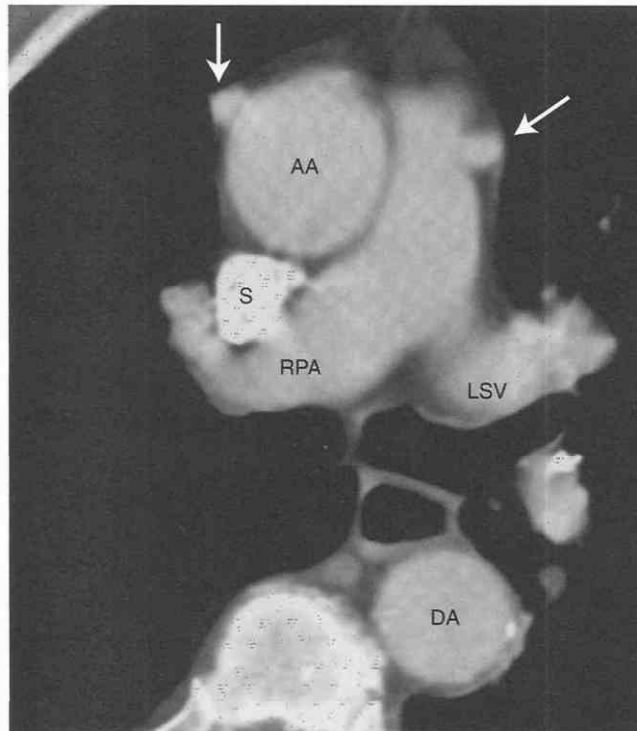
Coronary artery bypass grafts. Contrast-enhanced axial CT image shows enhancement of right and left coronary artery bypass grafts (arrows). AA, ascending aorta; DA, descending aorta; LSV, left superior pulmonary vein; RPA, right pulmonary artery; S, superior vena cava.
